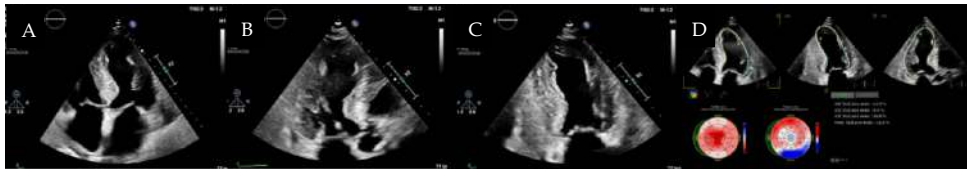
Apical 4-chamber (A), 3-chamber (B), and 2-chamber (C) views in a patient with cardiac amyloidosis (left ventricular wall thickness and sparkling). On the bull's eye strain images (D), the apical sparing pattern is displayed (right image).
